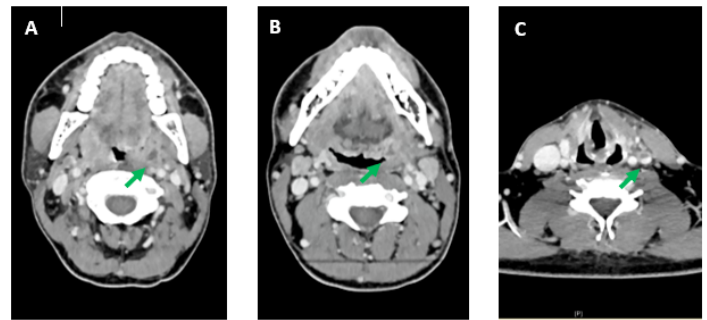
Contrast-enhanced computed tomography demonstrating parapharyngeal abscesses (contrast enhanced and thickened wall) (A, B) and a lack of contrast medium in the left internal jugular vein (C).
